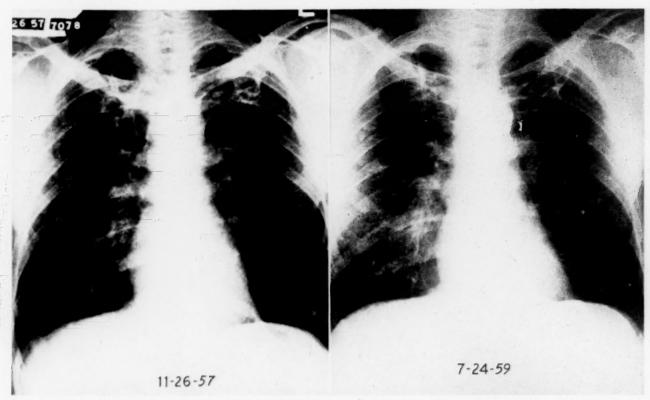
Roentgenograms of patient C. T. demonstrated good improvement, although not complete clearing, during twenty months of continuous drug therapy. This patient's sputum converted after three months therapy; he was discharged from hospital after four months and has been working full time as a service station operator during the last twelve months of his drug treatment.
